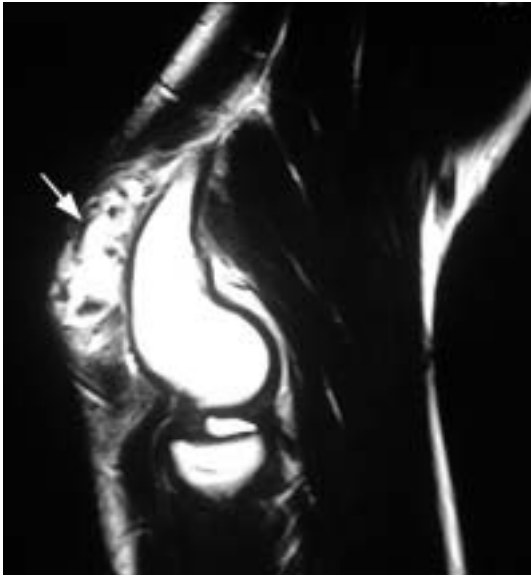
Magnetic resonance images show synovial proliferation (indicative of signal attenuation by the haemosiderin) as an isointense to mild hyperintense signal with the surrounding muscle in T1-weighted image and as high signal intensity in a T2-weighted image
